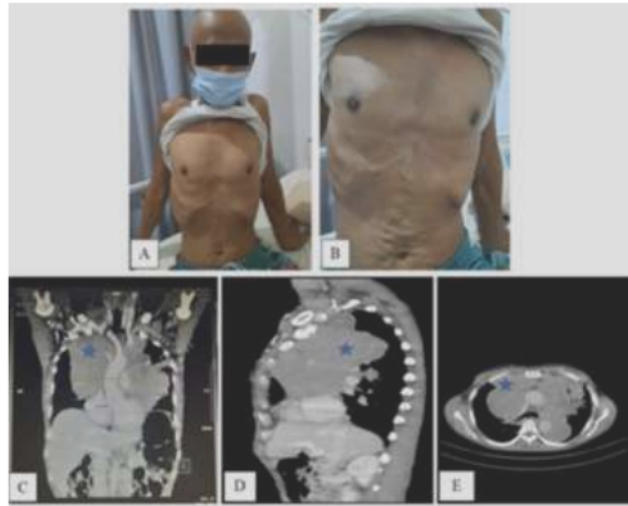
Signs of superior vena cava syndrome. A. Venectation of the patient's abdominal B. Venectation on thoracic anterior veins. C. Thorax CT scan with coronary section D. Sagittal segment CT scan. E. Axial section. The proximal paraaortic abdominals and the superior vena cava are both compressed and narrowed by the apparent mass in the mediastinum (asterisks mark) on the right-left side from anterior to posterior.
